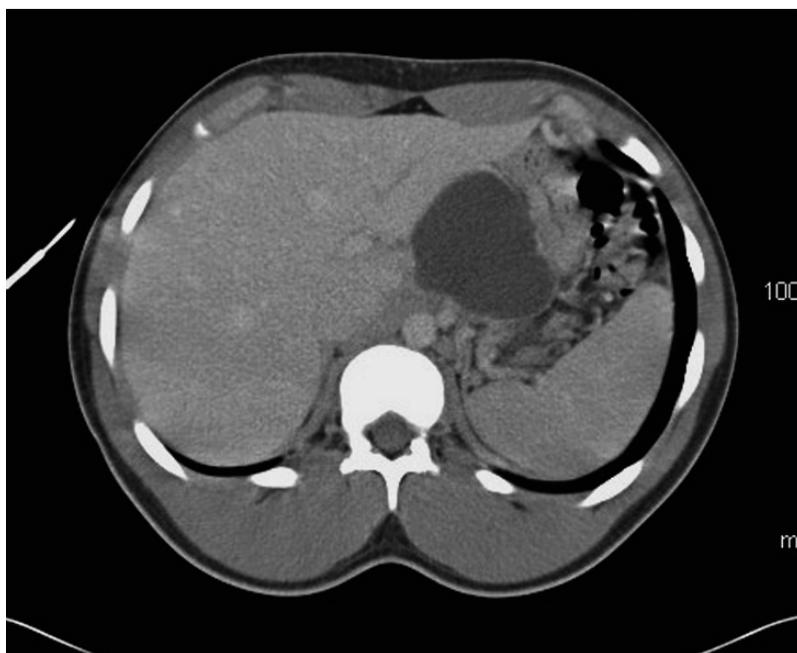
CT scan of a patient with a pancreatic pseudocyst 8 weeks after blunt abdominal trauma.
